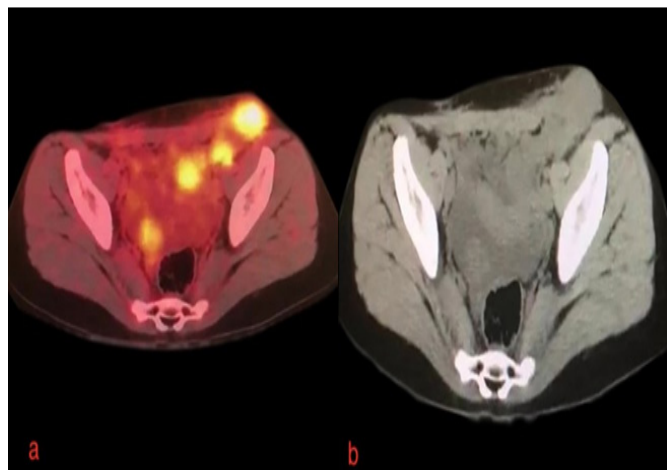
First post-operative F-18 FDG PET/CT images. Fusion image (a) and CT image (b)
